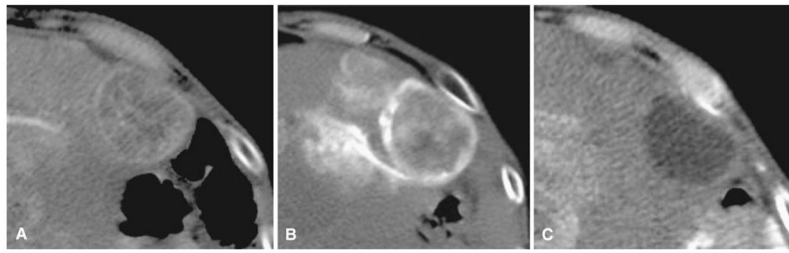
22-year-old woman with metastatic neuroendocrine tumor to liver. A Arterial phase preprocedure contrast enhanced CT shows index tumor in left lobe. B Immediate postembolization CT shows grade 1 TCR with grade 2 VCR without DCR. C Followup contrast enhanced CT shows CR by mRECIST criteria
